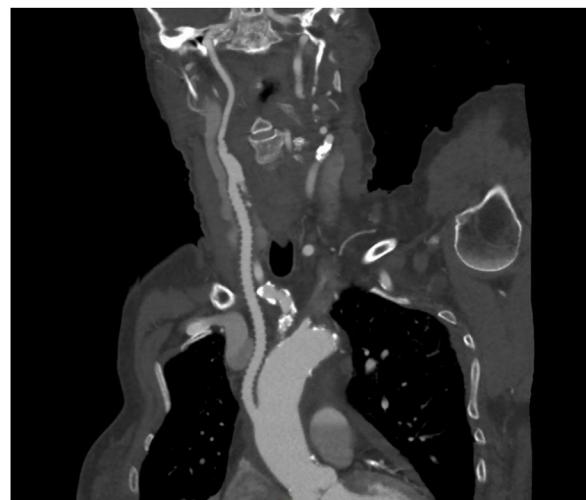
Reconstruction from computed tomography demonstrating patent aorto-carotid bypass graft.
